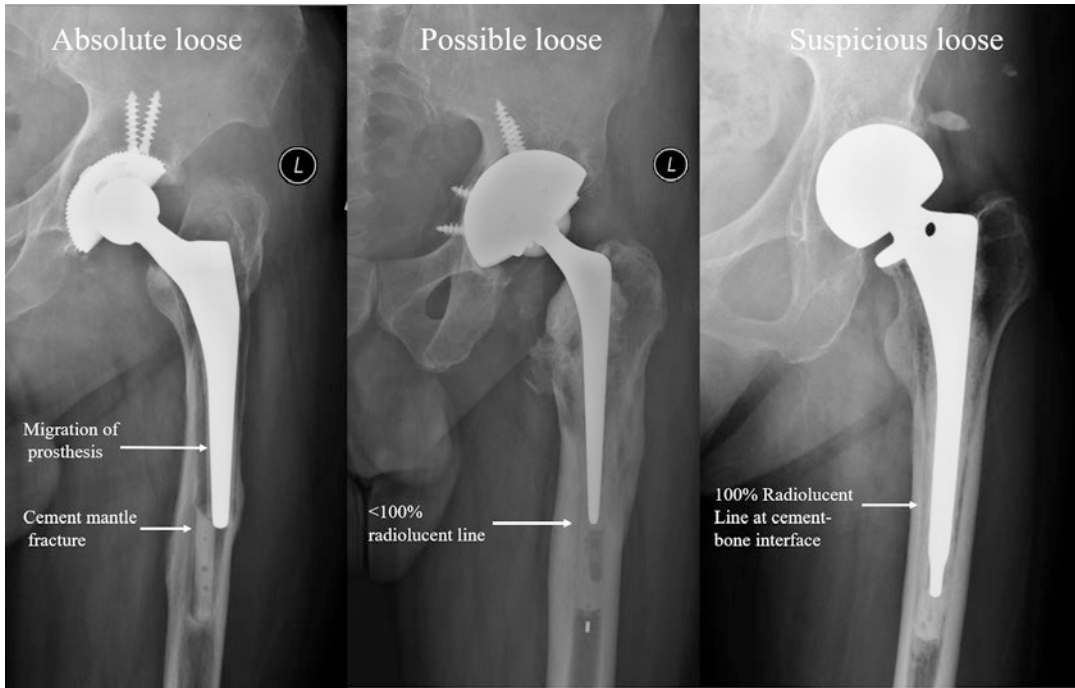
Radiographic assessment of cemented stem loosening
